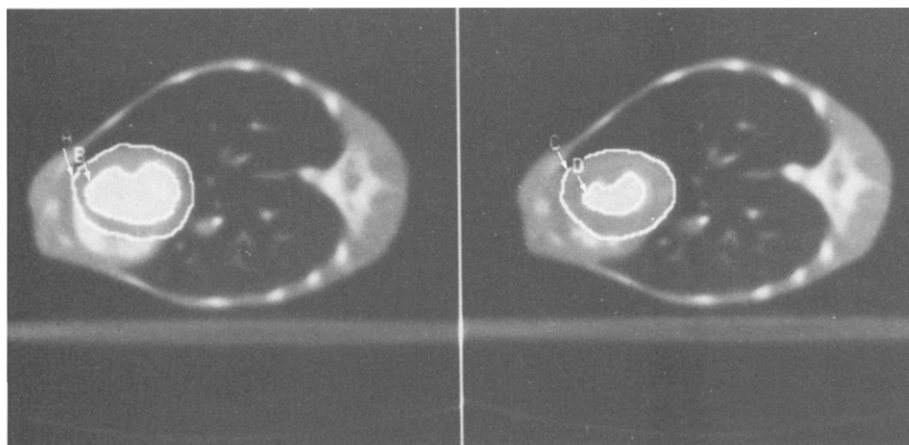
Definition of left ventricular edges. Shown are end-diastolic (left) and end-systolic (right) images at midventricular level. Left ventricular end-diastolic outer (A) and inner (B) boundaries and end-systolic outer (C) and inner (D) boundaries are displayed (arrows). Computed tomographic pixel values of ventricular edges are calculated and outlined as described in the Methods section.
